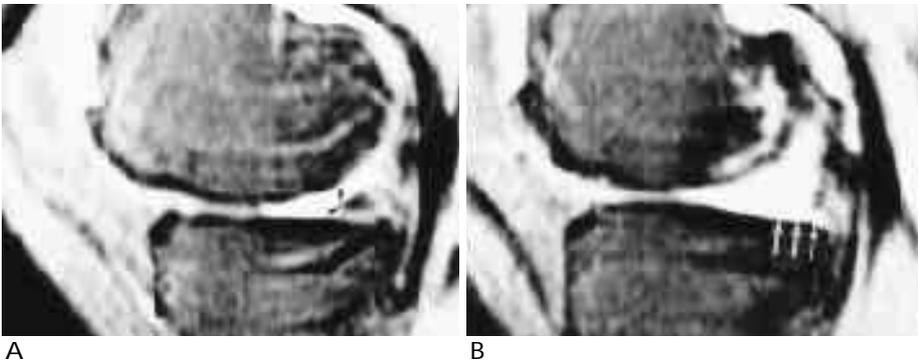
Sagittal proton density-weighted fat-suppressed fast SE MR images (TR/TE, 3000 msec/16 msec) of right knee in a 57-year-old man with radial tear of posterior horn of the medial meniscus. Blunting of apex (black arrowheads) and abrupt complete absence (white arrows) of meniscus are seen on consecutive images (A-B: medial to lateral direction).
